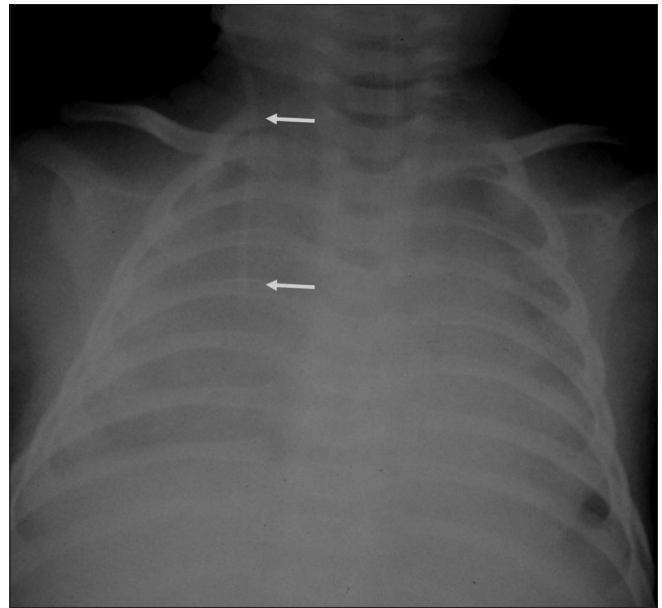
Frontal chest radiograph of a patient who was receiving fluids through a right jugular central venous catheter (arrows) shows an opaque right hemithorax (which was a fresh finding compared to earlier normal radiographs). This was due to vessel perforation by the catheter and resultant accumulation of fluid in the pleural space
